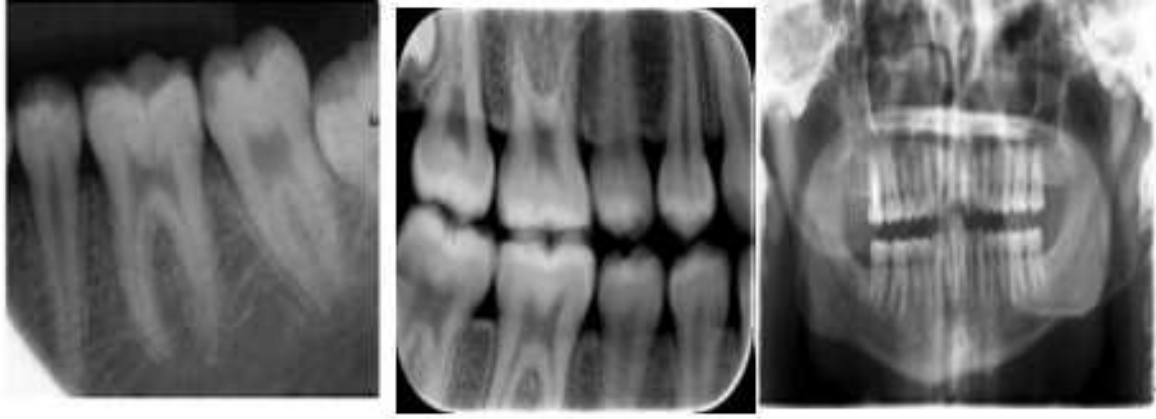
Periapical radiograph, Bitewing radiograph, Panoramic radiograph respectively [31].
